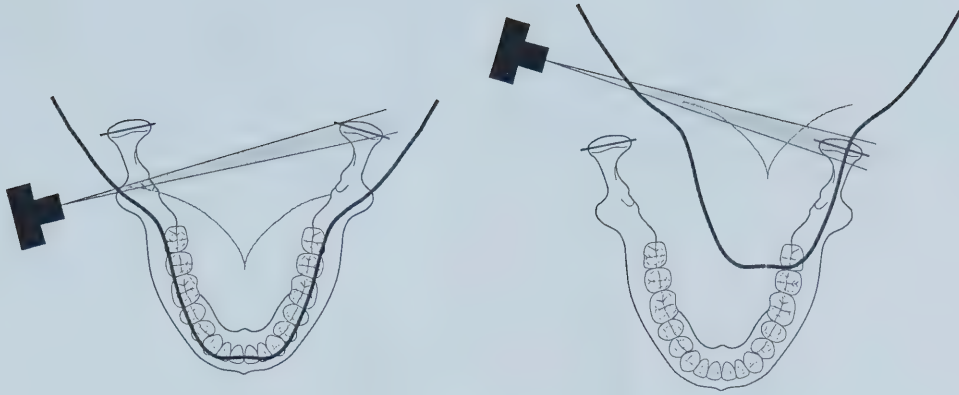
Head Positioning for Panoramic Imaging of the TMJ. In conventional panoramic radiography, the x-ray beam is directed at an oblique angle relative to horizontal axis of the condyle. When the patient's head is displaced forward and laterally towards the x-ray source, the x-ray beam can be directed parallel to the horizontal axis of the condyle. (From Goaz PW: White SC 1994; 12: 251)
